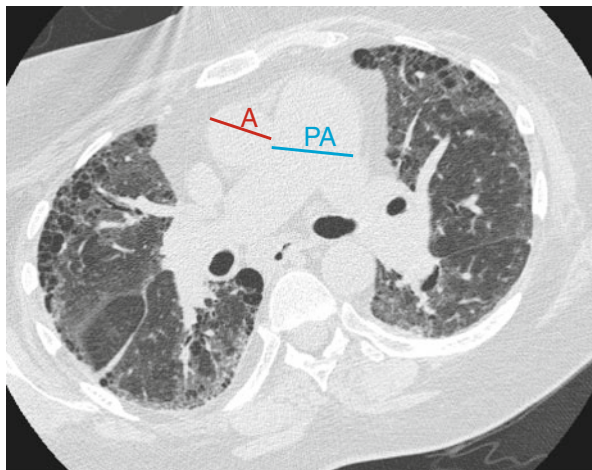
Enlarged pulmonary artery segment on computed tomography scan. The ratio of the pulmonary artery (*blue line*) to the aorta (*red line*) ($PA/A > 1$) is predictive of survival in IPF
